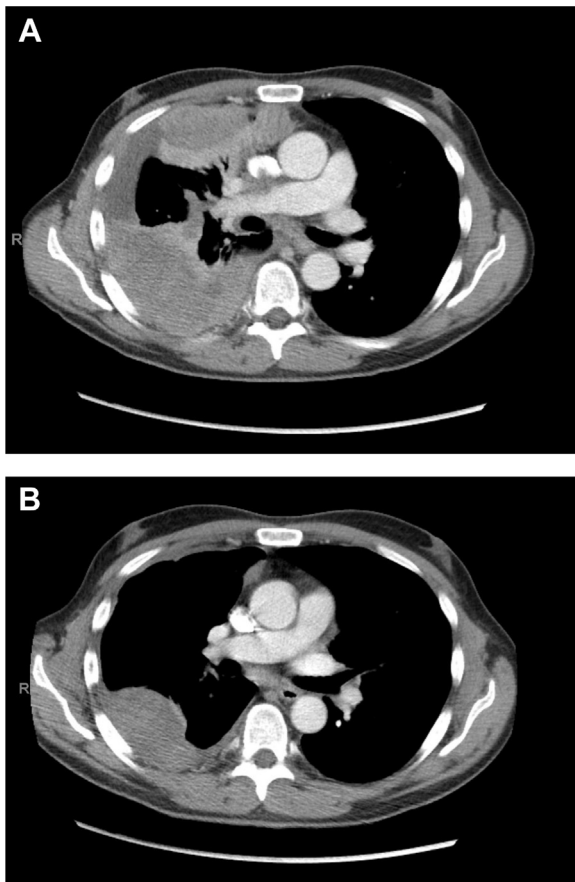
CT scan of the chest with contrast before and during treatment. (A) Baseline scan revealed a 4 cm mass and 2.1 cm nodule in the right lower lobe, multiple right-sided pleural masses measuring up to 14 cm, pleural effusion, and mediastinal and hilar lymphadenopathy. (B) CT scan after three cycles of carboplatin, paclitaxel, and pembrolizumab, which revealed a marked decrease in the pleural-based masses (i.e., 2.8 cm × 2.8 cm, previously 7.6 cm × 5.3 cm) and in the mediastinal lymphadenopathy (i.e., 1.7 cm × 1.3 cm, previously 4.3 cm × 4.1 cm). CT, computed tomography.
